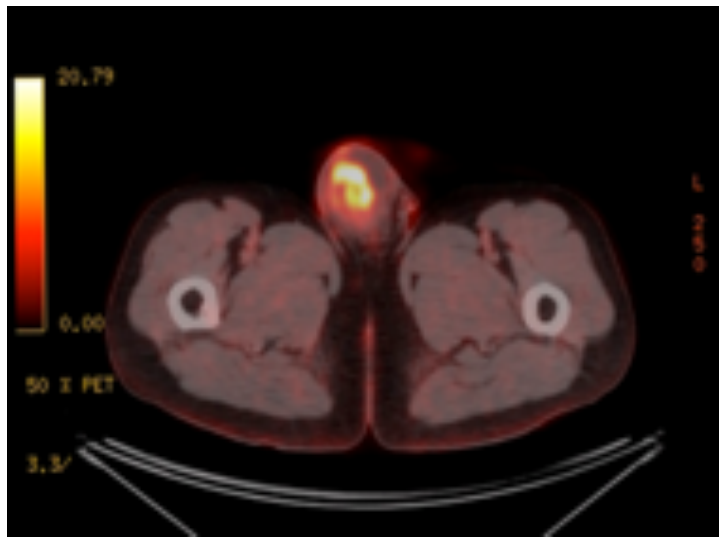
Whole body 18F-FDG PET/CT scan showing hypermetabolic right testicular lesion.
